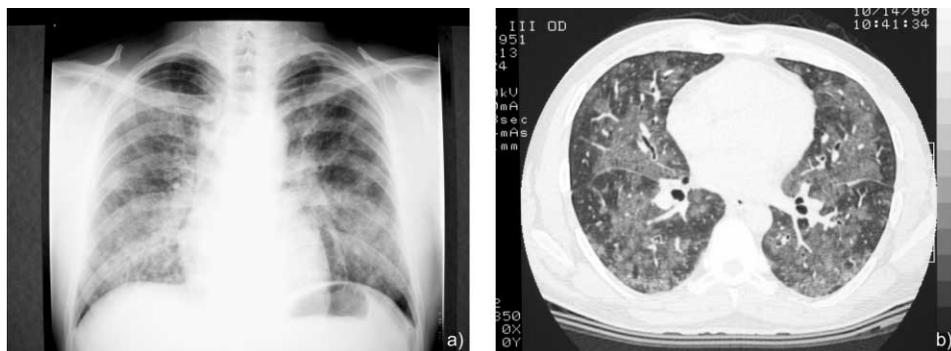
Sub-acute extrinsic allergic alveolitis. a) ILO standard radiograph, u/t 2/2, ground-glass opacity; b) CT-scan »mosaic perfusion« diffuses ground-glass opacity, hyper-transradiant pulmonary lobules due to coexisting bronchiolitis
